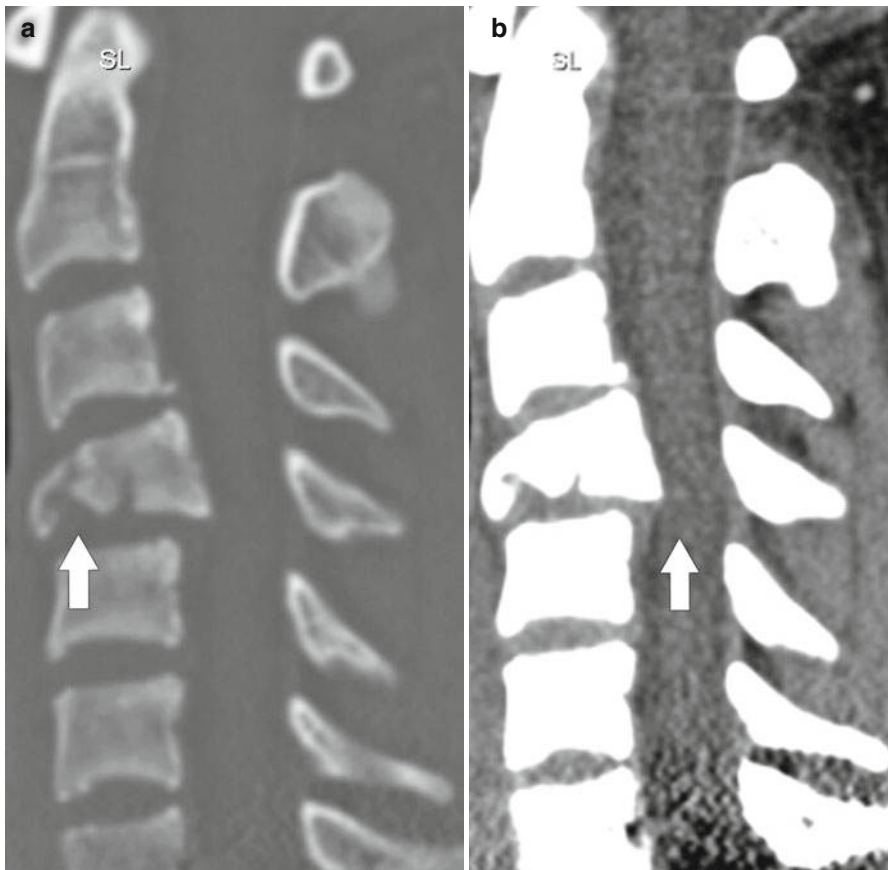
Unstable cervical spine fracture with cord compression. Cervical spine CT sagittal (SL) reconstruction images in bone window (a) reveals a C4 fracture (arrow). Corresponding image in soft tissue window (b) reveals cord compression (arrow)
